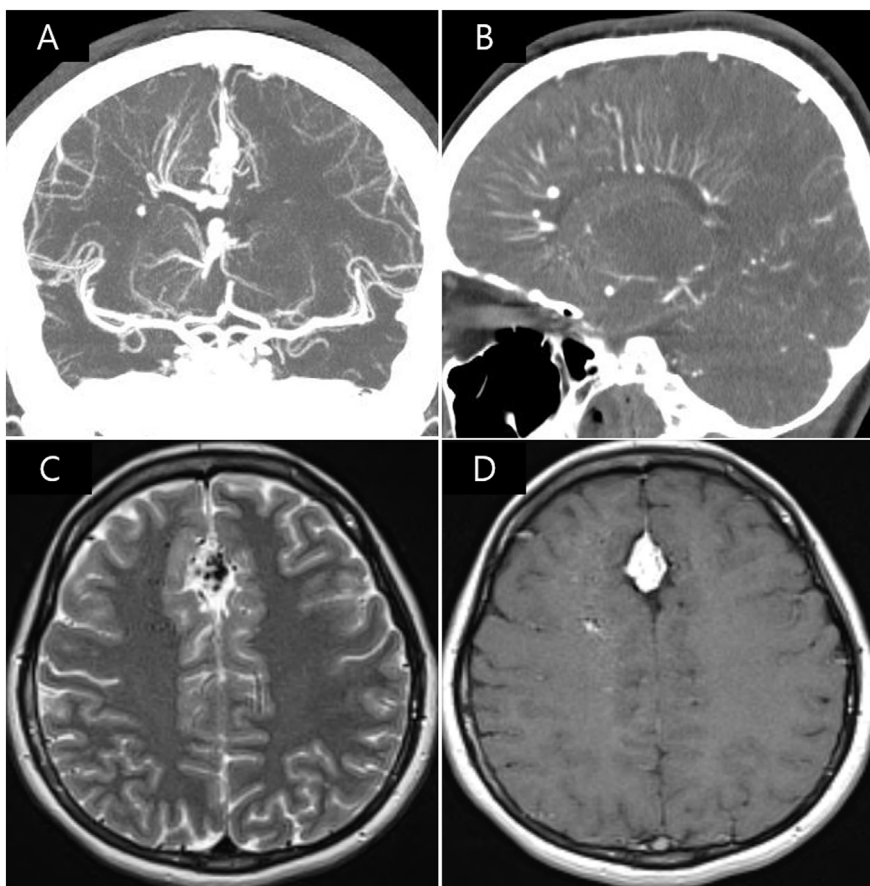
Computed tomography angiography (CTA) and magnetic resonance imaging performed at admission. A: A coronal computed tomography angiogram shows an oval, well-enhanced dilated vascular lesion in the anterior interhemispheric fissure coursing directly toward the superior sagittal sinus. B: Paramedian section of the right hemisphere on the sagittal computed tomography angiogram with vascular lesions characterized by caput medusae centripetally. C: An axial T2-weighted image shows multiple signal voids in the falx area. D: An axial enhanced image shows a well-enhanced mass-like lesion in the falx cerebri.
